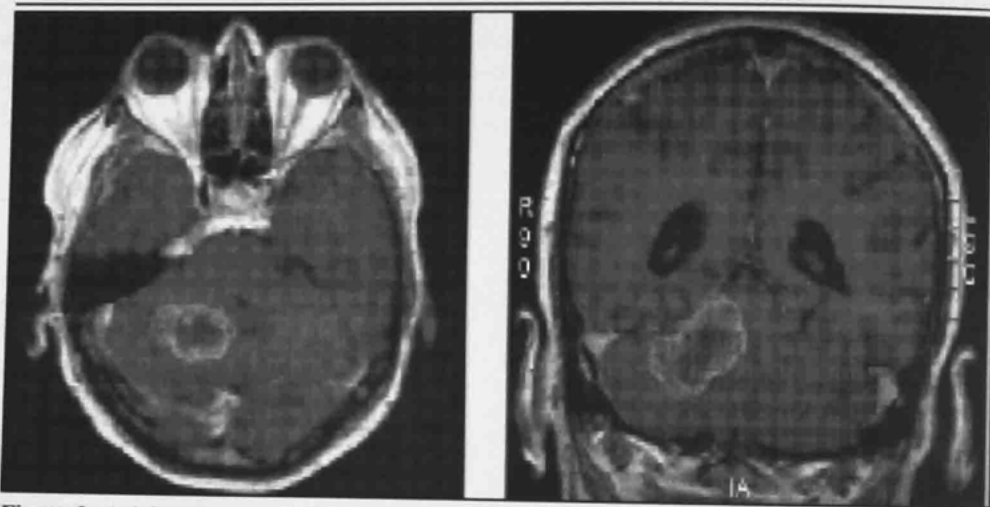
Axial and coronal MRI images of a 55 year old male with a cerebellar metastasis.
